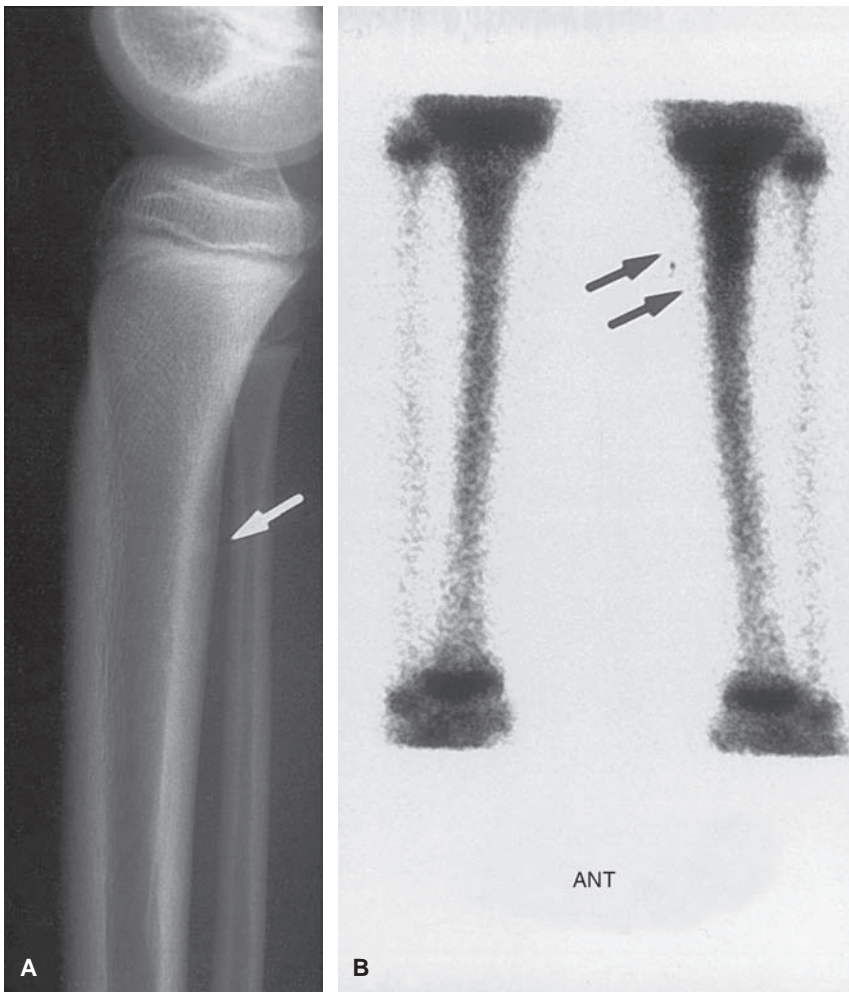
A: Routine radiographs of this 10-year-old girl revealed only a minor cortical irregularity of the posterior aspect of the proximal left tibia (*arrow*). B: Bone scintigraphy was performed. The increased isotope uptake seen along the proximal left tibia (*arrows*) confirmed the clinical suspicion of a stress fracture.
